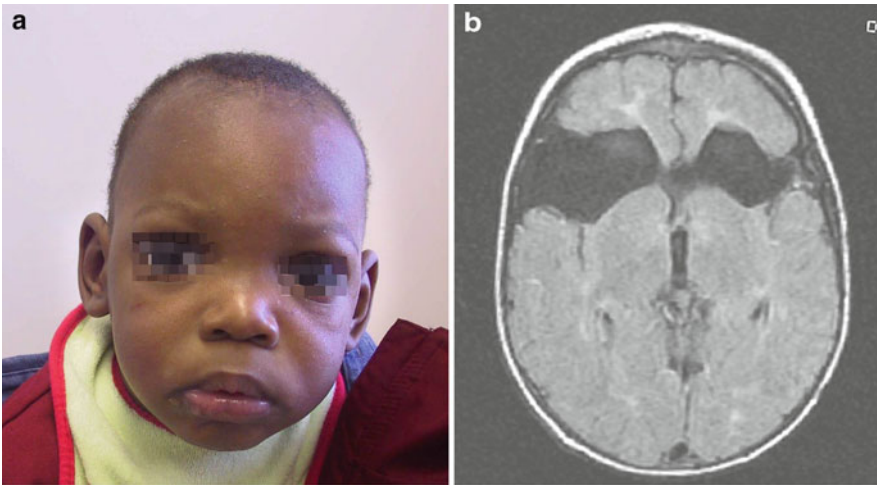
(a, b) An infant (a) with schizencephaly, global delay and spastic quadriplegia. His MRI of the brain showed bilateral large open-lip schizencephaly in frontotemporal regions (b)
